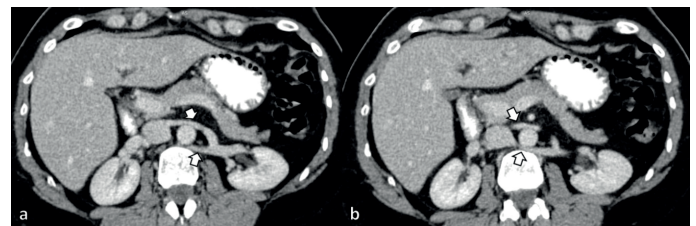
You can see circumaortic left renal vein (white arrows) of axial enhanced abdomen CT images (a, b).
